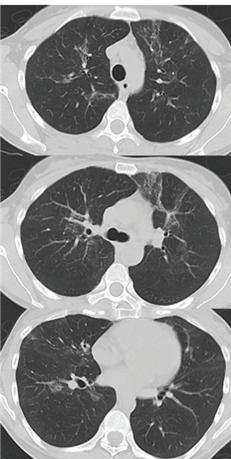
Chest X-ray and computed tomography (CT) scan 4 weeks after onset, showing marked improvement.
